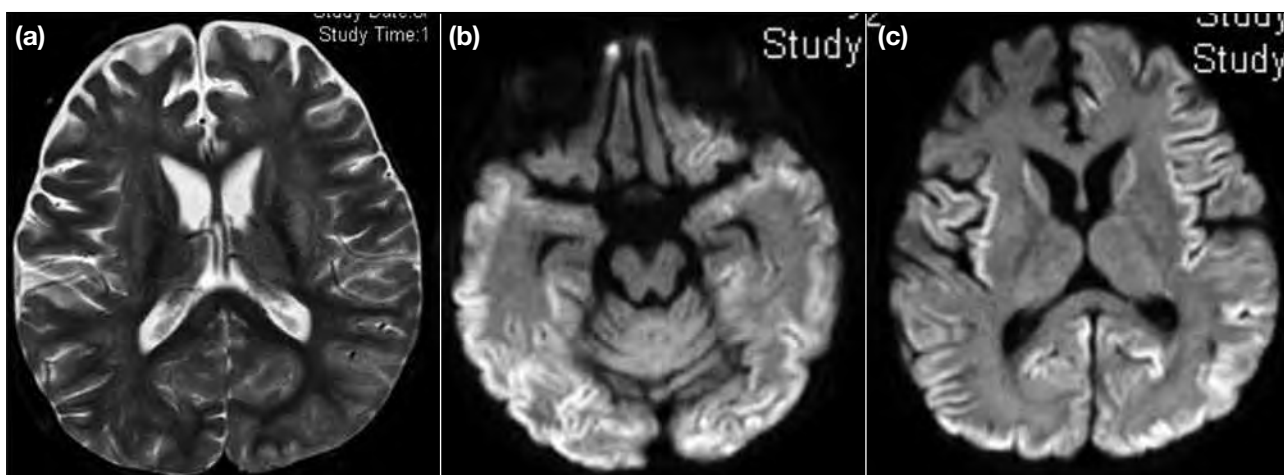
Patient 3. Magnetic resonance imaging scans showing (a) high-intense T2 signal at the deep grey matter; and (b, c) extensive restricted diffusion along bilateral cerebral gyri and subcortical white matter and at bilateral insular cortex and caudate nuclei.
